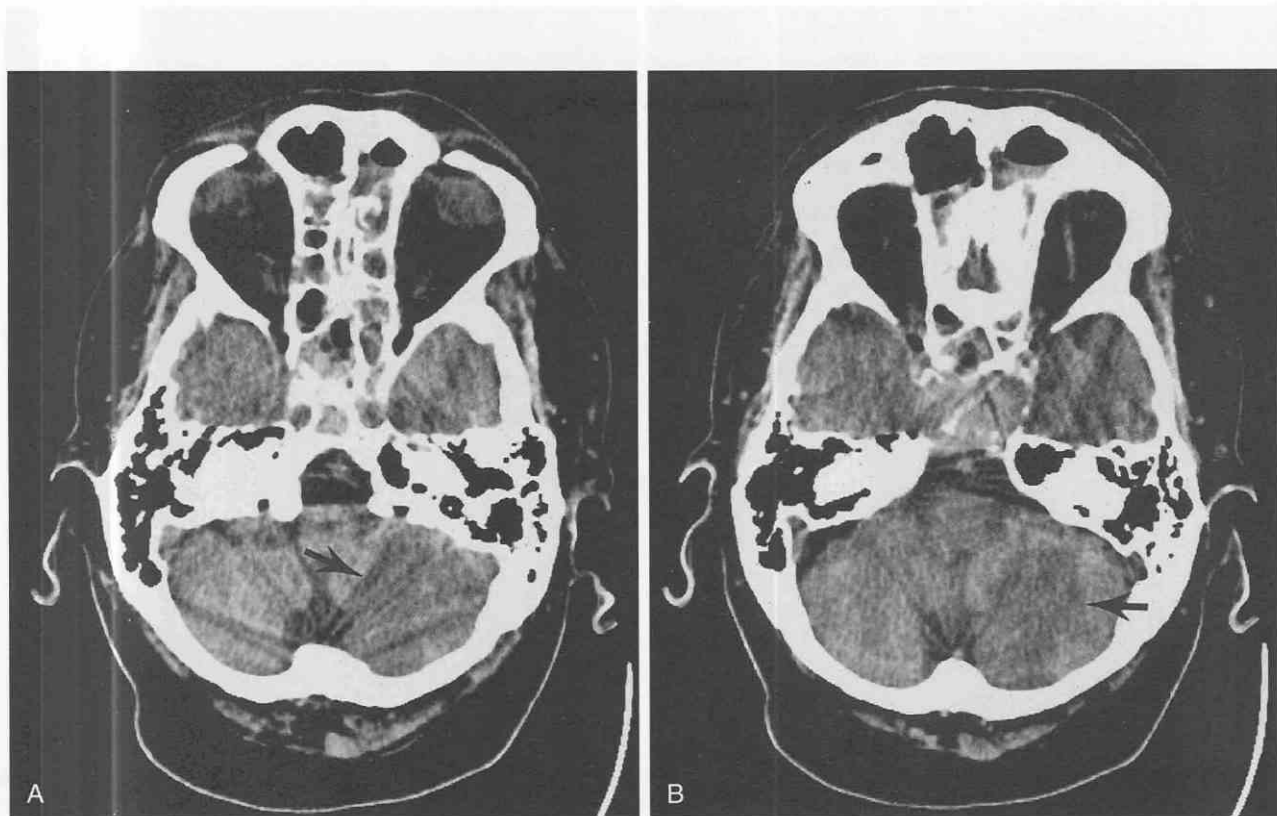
Stroke of the posterior inferior cerebellar artery. A and B, Unenhanced CT scan shows well-defined hypodensity in the distal territory of this artery (*arrows*).
